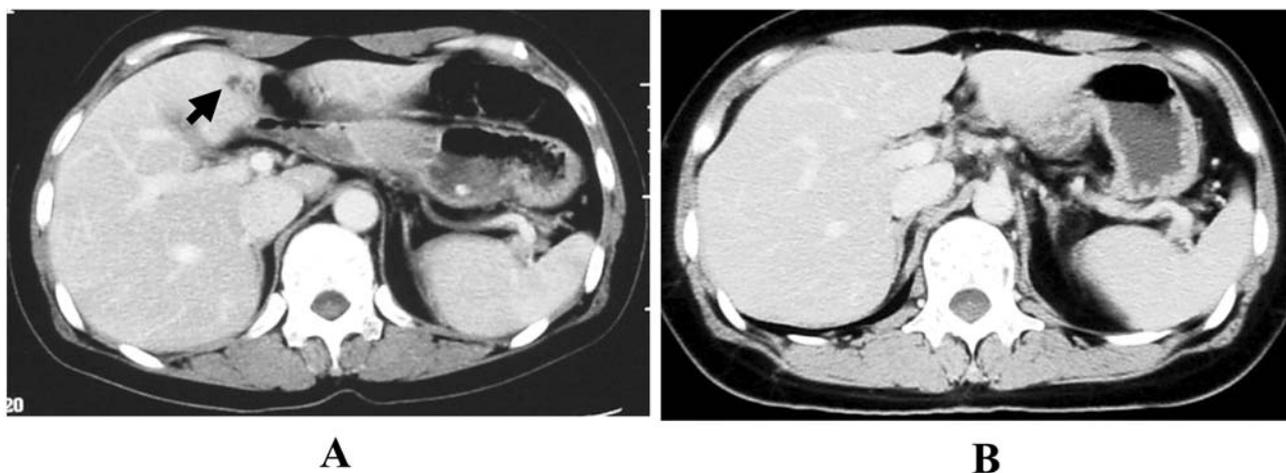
Disappearance of a liver metastasis in a patient with immunocell therapy alone. CT scan in Patient 2 on 19 April, 2000, showed a small metastatic lesion in the liver (A). The lesion could not be seen on rescan on 25 May, 2000 (B).
